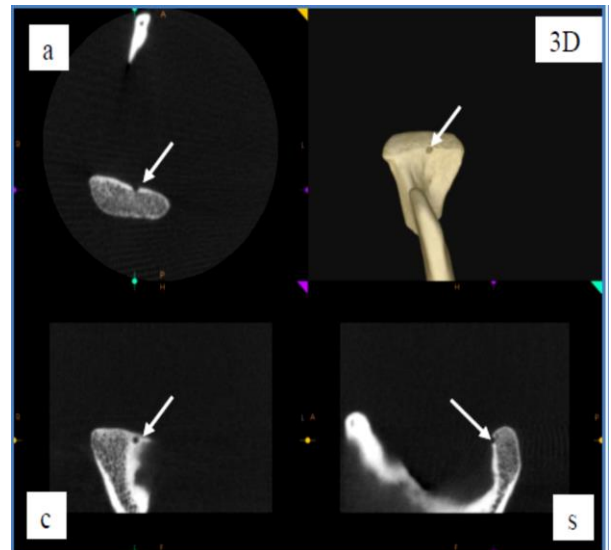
CBCT images of the same condyle demonstrating the lesion on anterosuperior surface in axial (a), coronal (c), sagittal (s) sections and 3D reconstruction (arrows)
